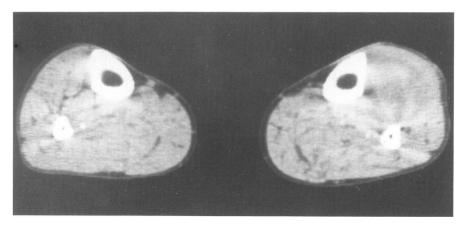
A fibrosarcoma of the anterior compartment of the leg is easily visible on CT scan with contrast. It cannot be determined whether the lesion has transgressed the interosseous septum to involve the posterior compartment.
